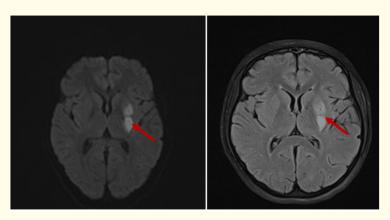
Diffusion and FLAIR: Left ischemic injury.
